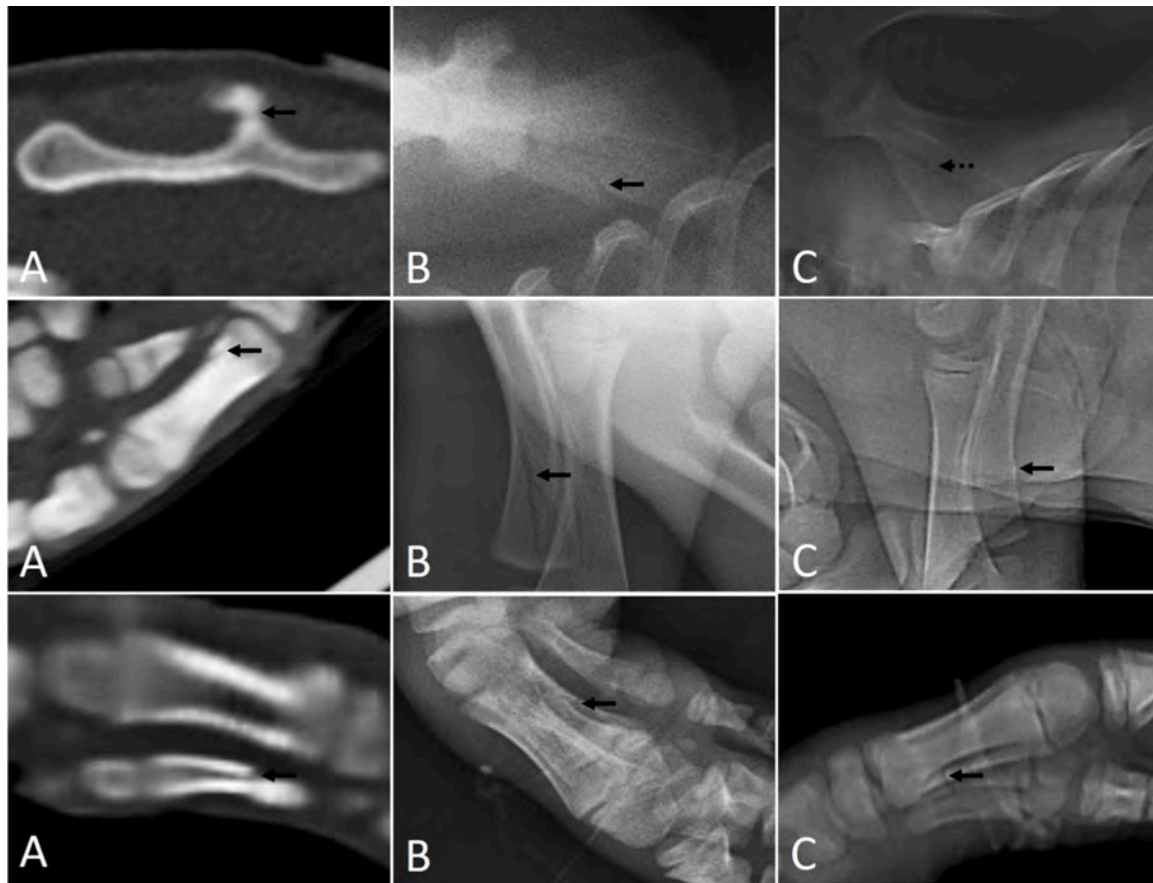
Frequently unidentified fractures of the anterior limb as shown by CT (A) (top: scapula; middle: metacarpal; bottom: metacarpal), X-ray (B) (top: scapula; middle: ulna; bottom: metacarpal) and Lodox® (C) (top: scapula; middle: ulna; bottom: metacarpal). Solid black arrows indicate fractures identified only by the SRR and NFA; dashed black arrows indicate fractures identified only by the NFA. A lack of white arrows indicates that none of the fractures were identified by all three observers.
